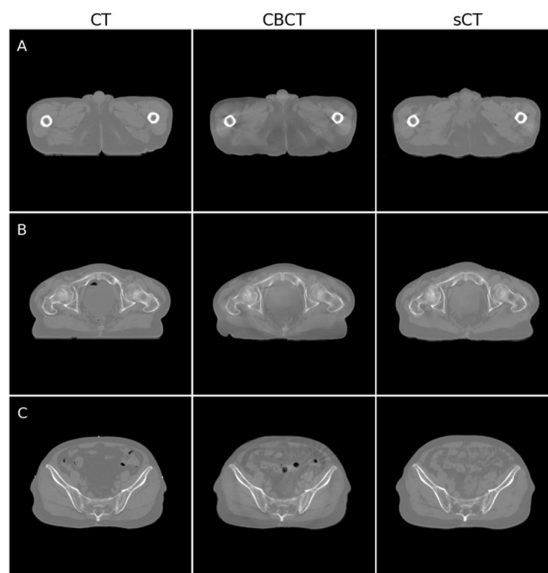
Visual examination of sCT images derived from CBCT data in the test dataset. Demonstrates sCT ability to reduce (A) streak artifact, (B) ring artifact and (C) star artifact as well as its limitation in preserving air pockets.
